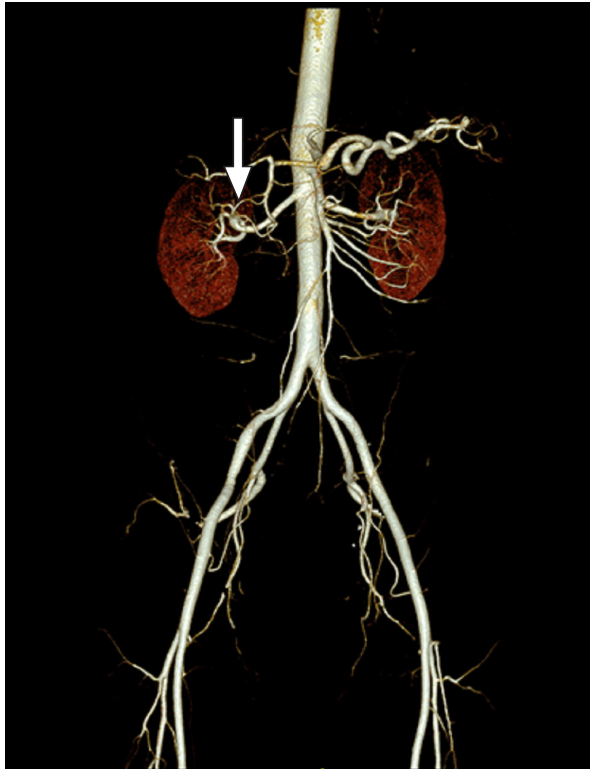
Computed tomogram (coronal view) shows the beading of the distal right main renal artery (arrow) with aneurysmal dilatation of the segmental right renal arteries, consistent with fibromuscular dysplasia.
